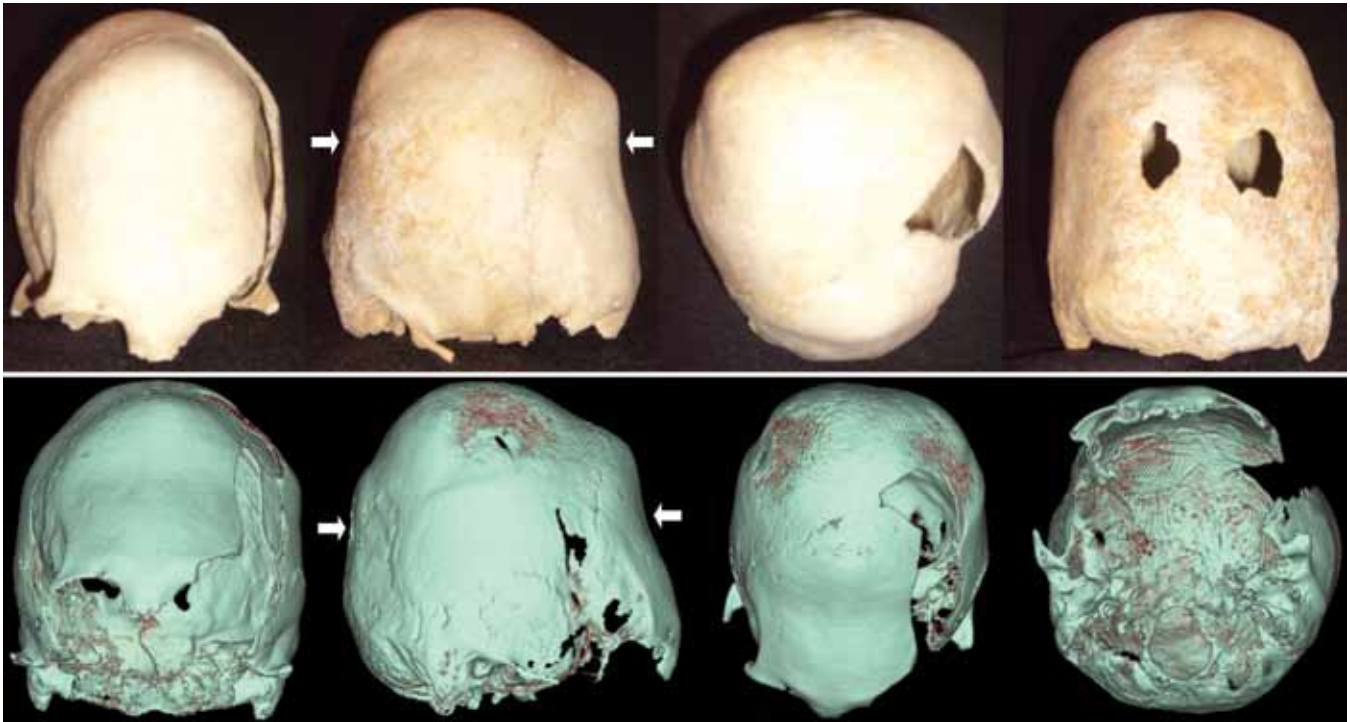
Photographs and 3D CT scans of an artificially deformed Proto-Bulgarian skull from the circular tomb near the city of Devnja, dating back to the end of the 9th century (see Kadanoff and Jordanov). The artificially deformed skull had been shaped with an erect form of anular intentional cranial deformation, caused by the tightening of one pressure bandage that encircles the forehead and the occiput. A: Photographs of the skull: anterior, lateral (notice the imprints of the pressure bandage—arrows), superior, and posterior. B: Series of 3D CT scans of the skull: anterior, lateral (notice the imprints of the pressure bandage—arrows), superior, and inferior (notice the absence of bony signs of elevated ICP).
